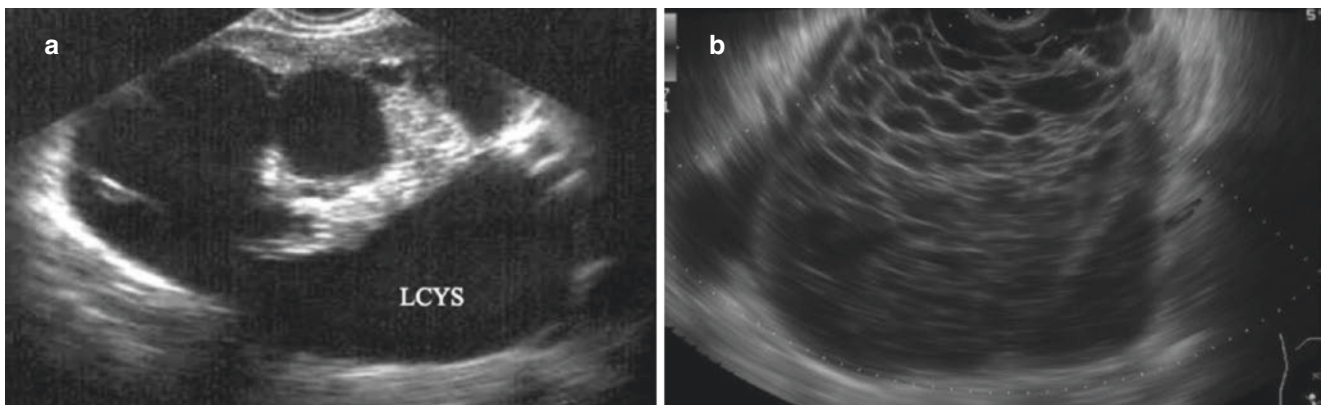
Ovarian malignant tumors (I). (a) Ultrasonic images show a septal cystic mass with thick septum, and pathological diagnosis is serous cystadenocarcinoma. (b) Ultrasonography shows cystic mass
